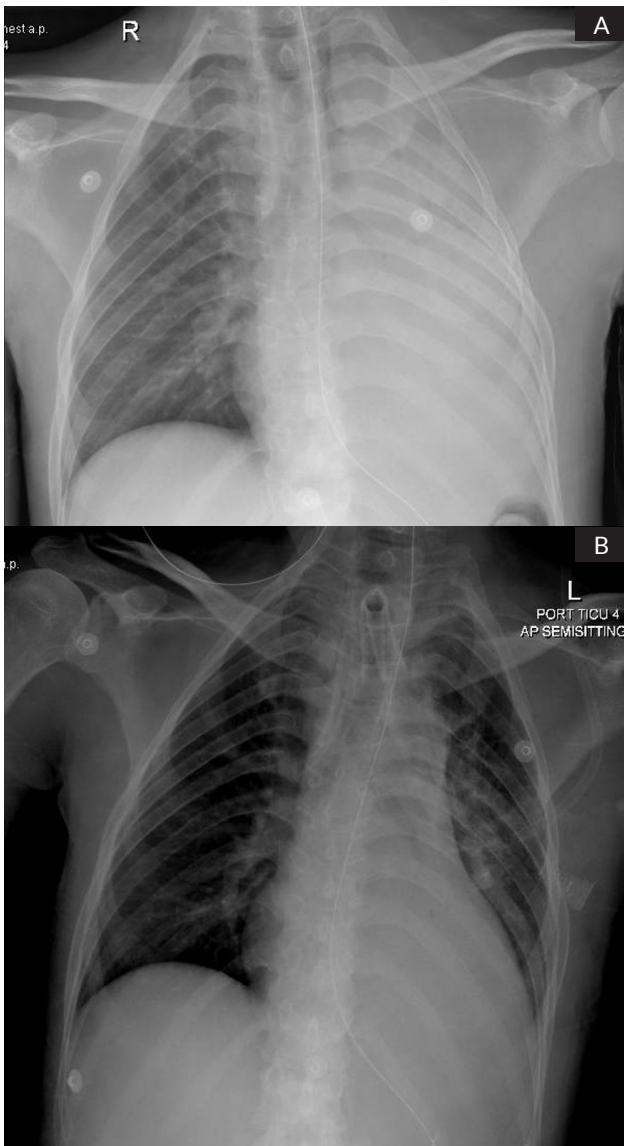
A) Chest X-ray showing left lung collapse; B) Post bronchoscopy and removal of secretions.
